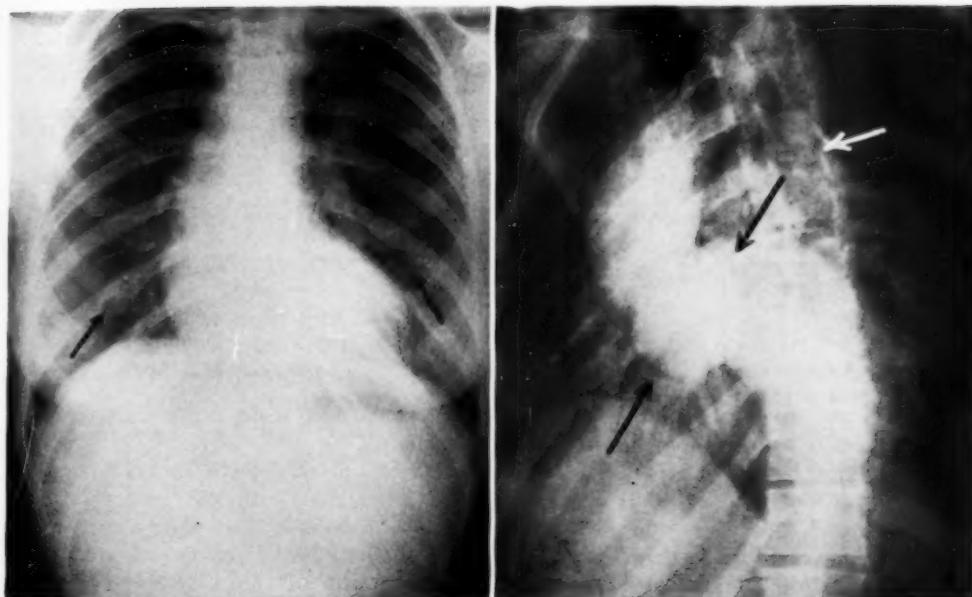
Roentgenogram showing notching of ribs (indicated by arrows).
